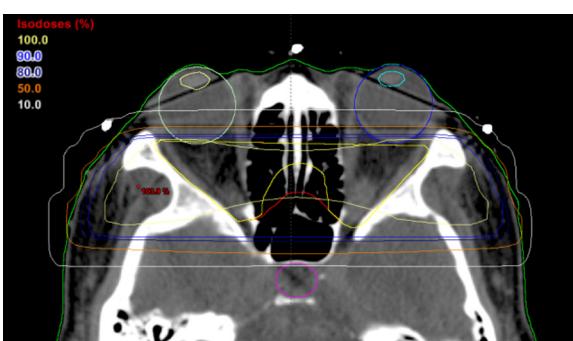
Example radiation planning on axial computed tomography (CT) image for patient with TED demonstrating areas of irradiation from the 10% to the 100% isodose lines.
